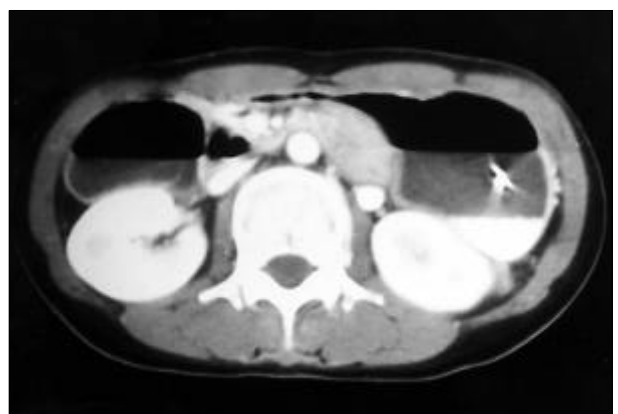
Case 2. 36-year-old woman. Contrast-enhanced Abdomen CT scan showing a compression of the duodenum between the aorta and superior mesenteric artery.
